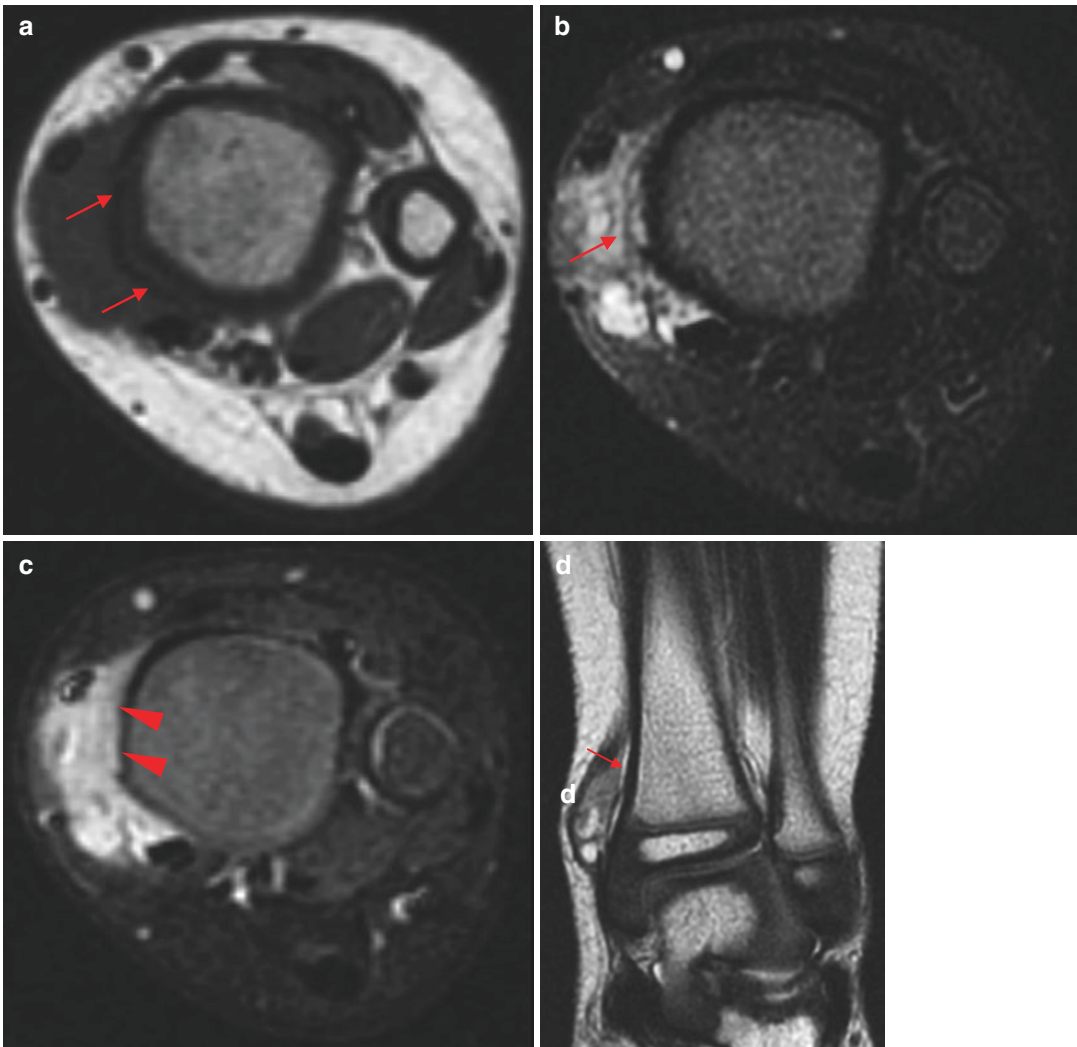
Retiform hemangioendothelioma. MR image of the ankle shows an irregularly bordered subcutaneous soft tissue mass that closely abuts the distal tibia. The lesion shows isointensity on T1WI (a), heterogeneous hyperintensity on FS T2WI (b), and intense contrast enhancement on postcontrast FS T1WI (c). The mass directly extends beneath the adjacent tibial periosteum
